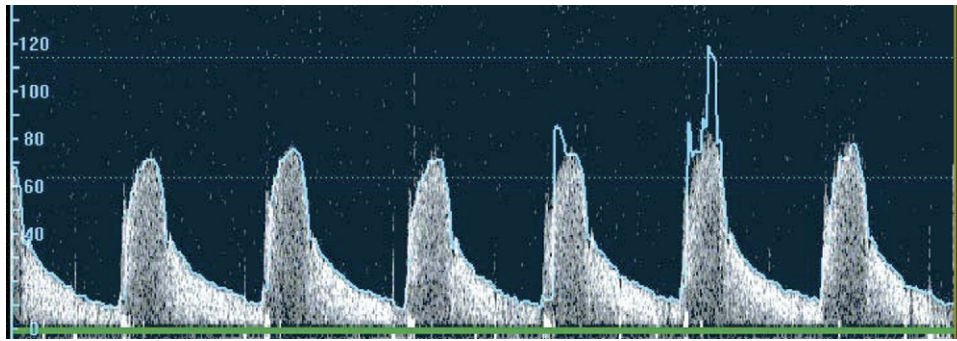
Example of invasive Doppler flow wire velocity waveforms in the mid renal artery. Peak systolic velocity here is 80 cm/s. End-diastolic velocity is 15 cm/s. This yields an RI of 81.
